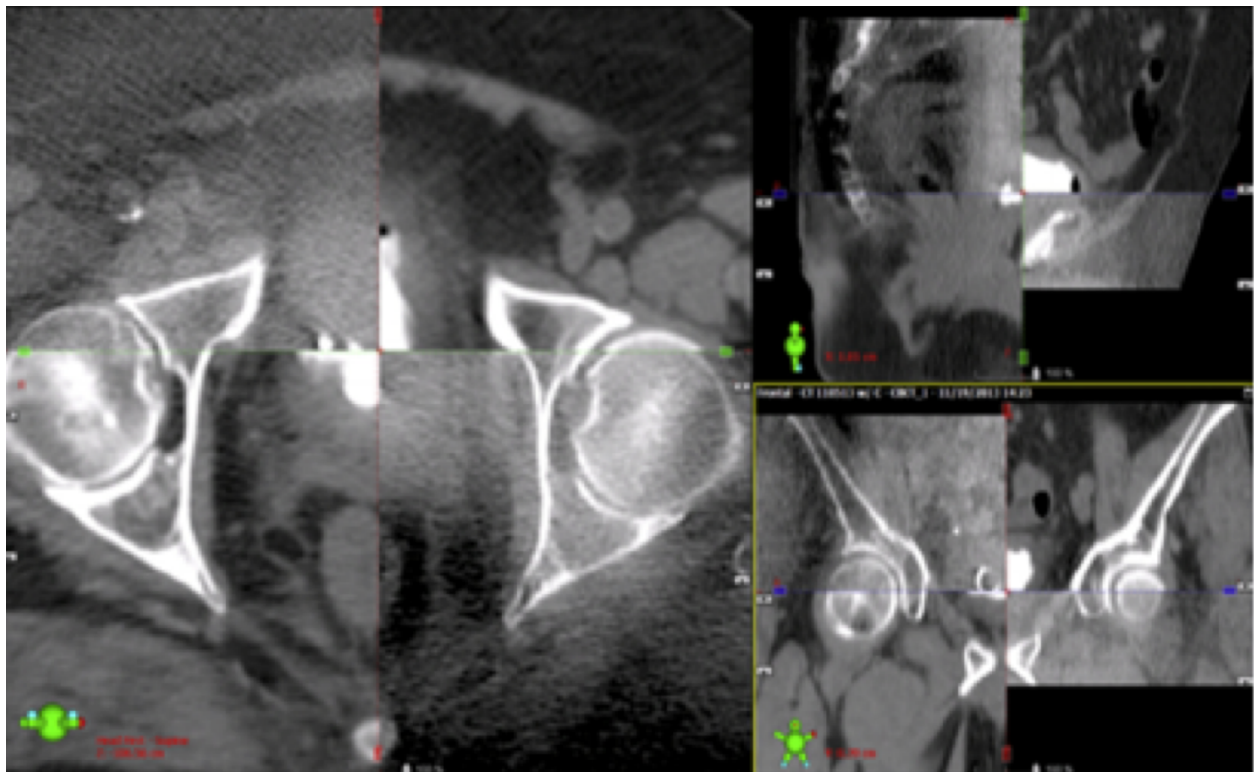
Cone beam CT fused with planning CT (Premo *et al.*, 2015)
